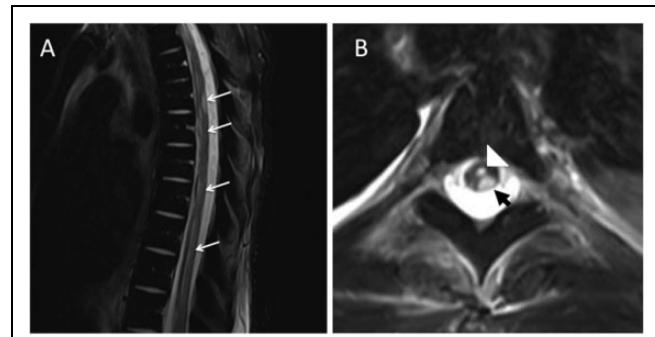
A, Sagittal T2-weighted magnetic resonance imaging (MRI) of the thoracic spine demonstrates a long segment of T2 hyperintense cord signal abnormality (white arrows). B, Axial T2-weighted MRIs of the thoracic spine (T5-T6 level) demonstrate T2 hyperintense cord signal abnormality, which predominantly involves the left dorsal column (short arrow). Prominence of the central canal is also seen (white arrowhead).
